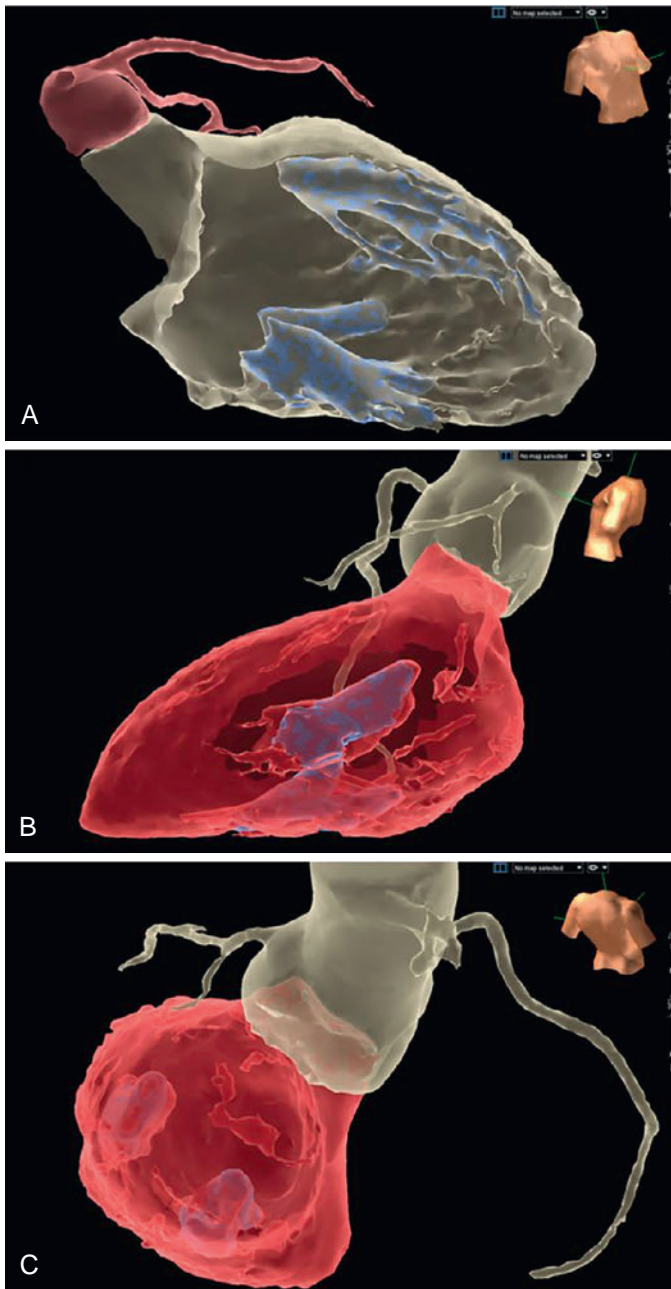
Anatomy of the Left Ventricular (LV) Papillary Muscles. (A) Three-dimensional reconstruction of the cardiac multidetector computed tomography and integration to the mapping system guided by intracardiac echocardiography. This corresponds to a lateral view of the endocardial aspect of the LV. The papillary muscles are depicted in blue, whereas the aortic root and left coronary artery are depicted in red. (B) Left lateral view of the LV and aortic root. The anterior papillary muscle in blue and the rest of the LV in red. (C) Posterior view of the LV (red) and aortic root (gray). Notice the anterior and posteromedial papillary muscles in blue. (From Rivera S, Ricapito Mde L, Tomas L, et al. Results of cryoenergy and radiofrequency-based catheter ablation for treating ventricular arrhythmias arising from the papillary muscles of the left ventricle, guided by intracardiac echocardiography and image integration. *Circ Arrhythm Electrophysiol.* 2016;9:1–9.)
